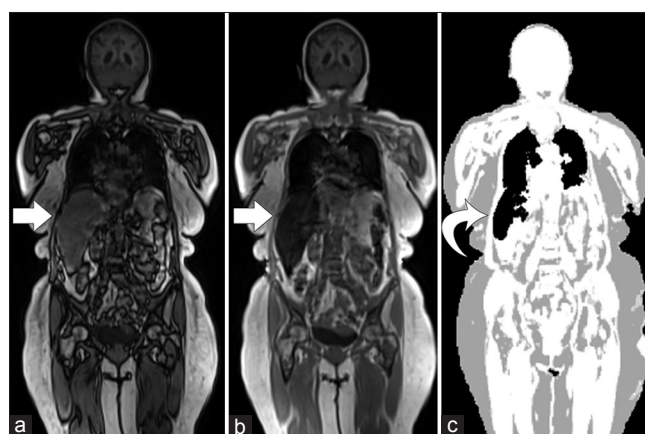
Dixon three-dimensional volumetric interpolated breath-hold examination T1-weighted magnetic resonance sequence in the coronal plane demonstrates normal signal intensity in the liver parenchyma (arrow) on the out-of-phase image (a) with drop in signal on the in-phase image indicating excessive iron accumulation (b). The mu map showed the expanded boundary of the right lung instead of the correctly assigned soft-tissue density of the liver parenchyma (curved arrow) (c)
